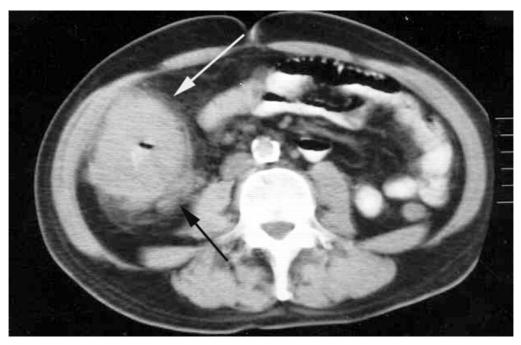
True-positive CT scan for serosal invasion (white arrow) and nodal involvement (black arrow)
